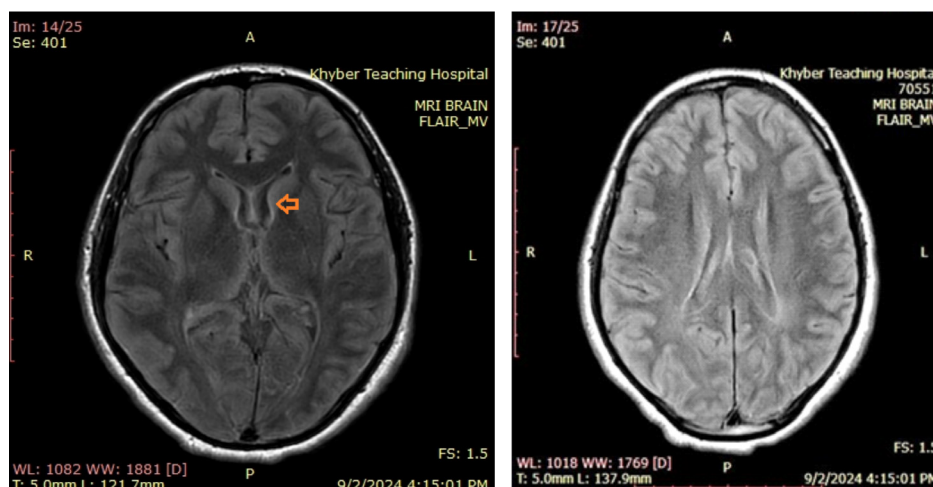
MRI Brain-FLAIR sequence: Shows Few discrete high signal foci in periventricular white matter and centrum semi-ovale region.
